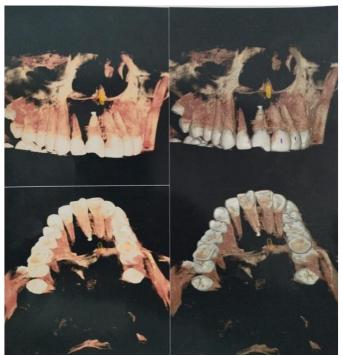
CBCT scan after endodontic treatment and before surgical enucleation
